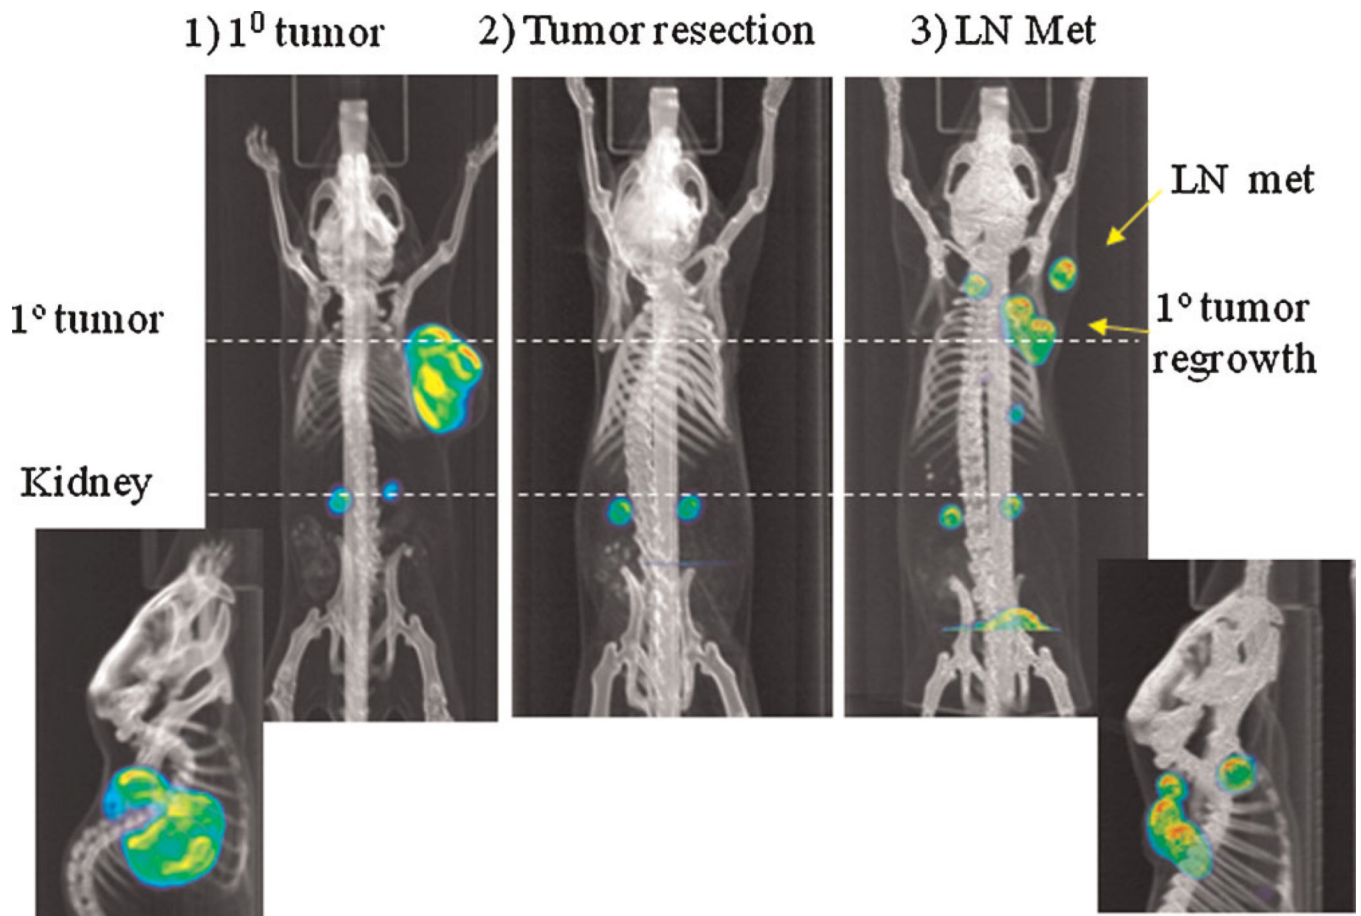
^{18}F -FLT PET-CT to monitor tumor growth and LN metastasis. Subcutaneous LAPC-9 tumor was visualized using ^{18}F -FLT at 4 week after tumor implantation (1, coronal view, with sagittal view of the tumor shown below). At this time point, primary tumor was resected (2). 21 days after tumor resection (3), FLT-PET showed primary tumor regrowth and dissemination to regional LN (yellow arrows), a sagittal view was shown below. [Color figure can be viewed in the online issue, available at wileyonlinelibrary.com.]
